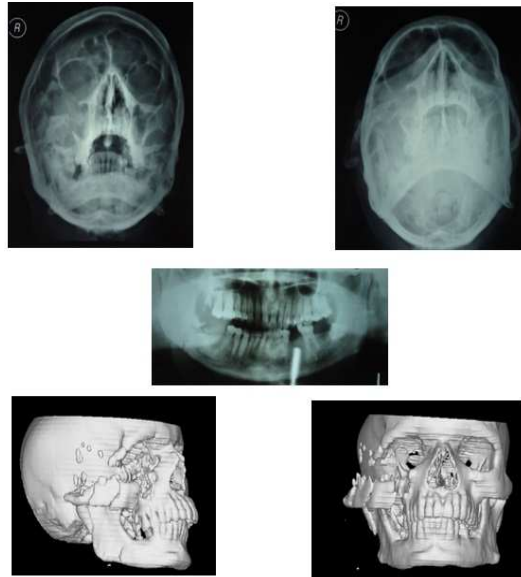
3D CT images of the comminuted fracture of complex, and Lefort II fracture. Fracture right ramus of mandible is also evident. Fracture displacement is more clearly demarcated on 3D CT
